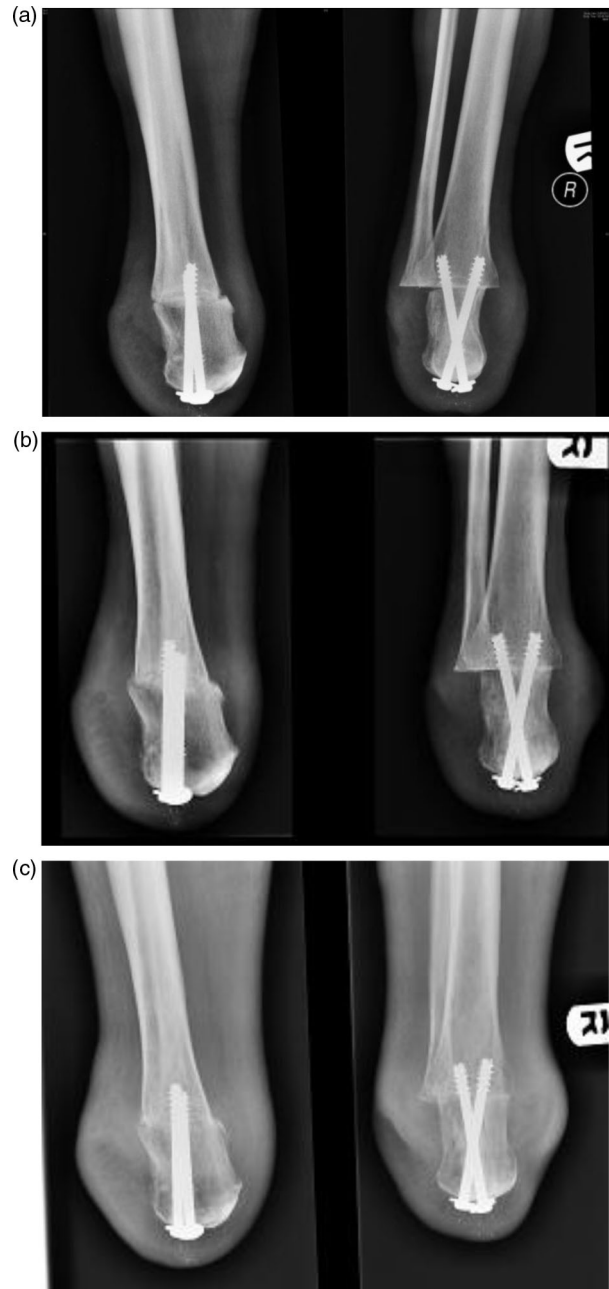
(a) Lateral and anteroposterior radiographic views of immediate postoperative modified Pirogoff's amputation showing compression of the tibio-calcaneal surfaces by two partially threaded cannulated screws. (b) Lateral and anteroposterior radiographic views of a Pirogoff's amputation showing the presence of initial union at the tibio-calcaneal arthrodesis at 3 months postoperatively. (c) Lateral and anteroposterior radiographic views of a Pirogoff's amputation showing the presence of significant union at the tibio-calcaneal arthrodesis at 6 months postoperatively.
